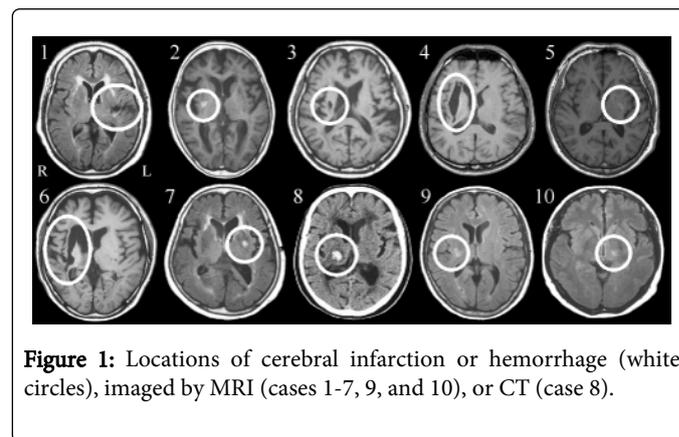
Locations of cerebral infarction or hemorrhage (white circles), imaged by MRI (cases 1-7, 9, and 10), or CT (case 8).
